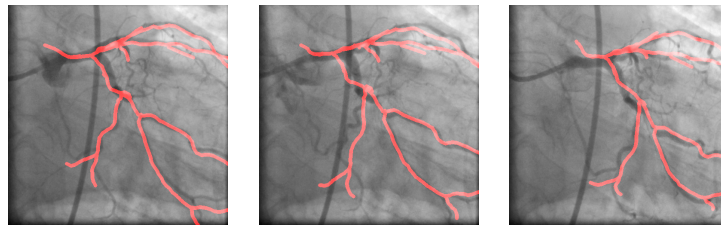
Motion-compensated CT-centerline overlaid on top of angiographic images at different cardiac phases; end-diastole, early systole and systolic peak (from left to right).
